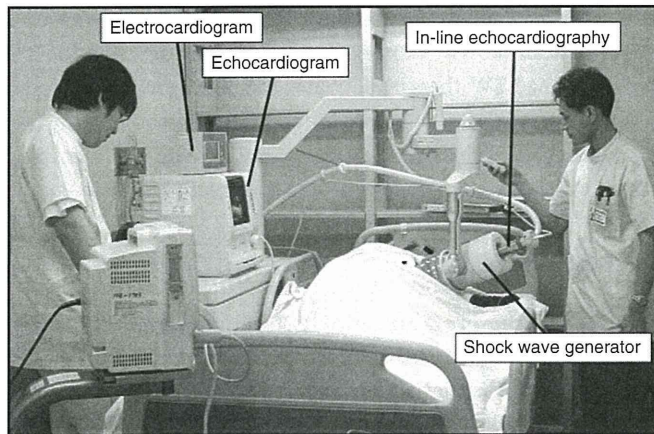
Extracorporeal cardiac shock wave (SW) therapy in action in a patient with severe coronary artery disease. The machine is equipped with a SW generator and in-line echocardiography. The SW generator is attached to the chest wall of the patient when used. The SW pulse is easily focused on the ischemic myocardium under the guidance of echocardiography. There is no need for anesthesia or sedatives.
